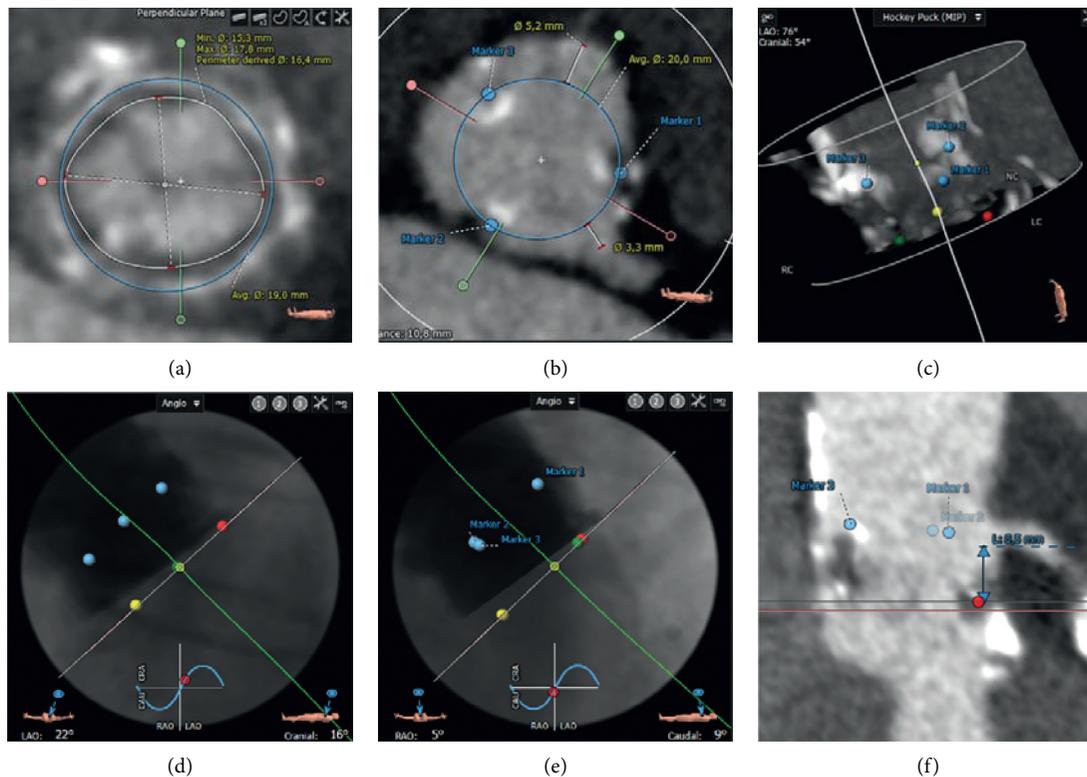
Preprocedural CT planning in a 91-year-old female patient with high-grade aortic stenosis (peak gradient 64 mmHg and mean gradient 35 mmHg) that underwent ViV-TAVI in a failed 21 mm Epic bioprosthesis. (a) The basal ring of the Epic valve is marked at the center of the cusps (red, blue, and green dots). The stent diameter is 19 mm, and true internal diameter is 16.4 mm (17 mm according to the aortic ViV app, with internally mounted leaflets). (b) The posts of the stent of the Epic valve are marked with generic markers (blue). The blue circle is centered on the surgical valve and represents the waist of the planned 23 mm Evolut valve. The distance between the virtual 23 mm valve (with the waist of 20 mm) and the left coronary (virtual transcatheter valve-to-coronary ostium distance, VTC) is low (3.3 mm). (c) Hockey puck view showing the generic blue markers on the top posts, while the colored markers are in the middle of the cusps at the base of the surgical valve. (d) Coplanar view with the left coronary cusp at the right side (red marker). (e) Cusp-overlap view with overlapping left and right coronary cusps (red and green markers). (f) Low left coronary height (8.5 mm) with shallow sinuses of Valsalva.
